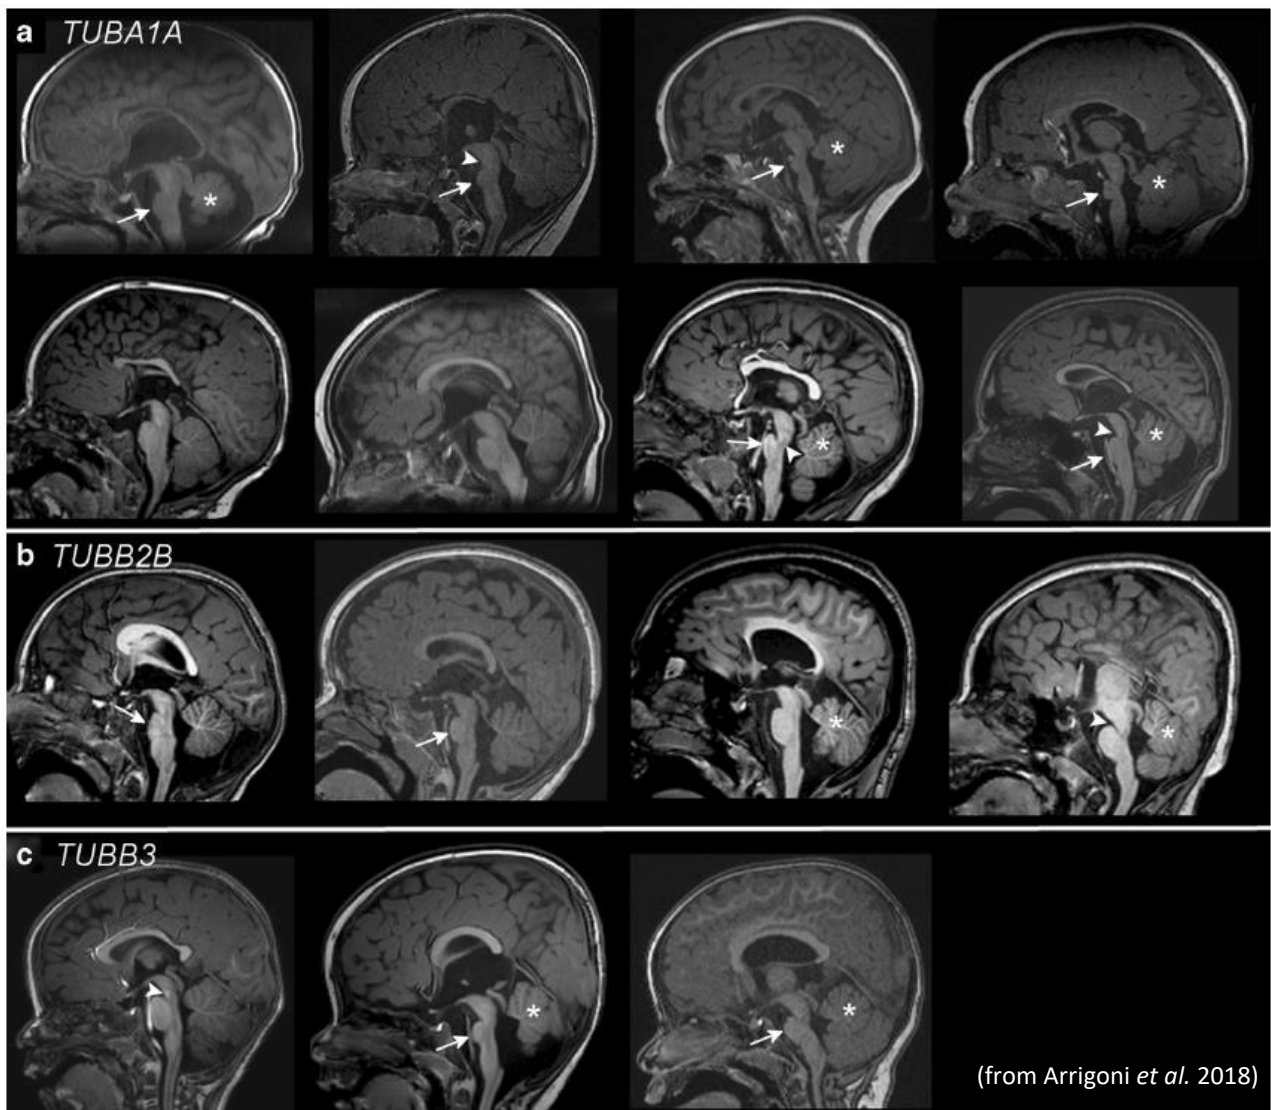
Brainstem appearance on sagittal sections. Midline T1-weighted sections show the heterogeneity of midbrain-hindbrain dysmorphisms in patients with mutations in *TUBA1A* (a), *TUBB2B* (b) and *TUBB3* (c) genes. Pons hypoplasia (arrows), irregular ponto-mesencephalic junction (arrowheads) and vermis hypoplasia (stars) could be noted in several patients. Corpus callosum malformations are also evident in all patients.
